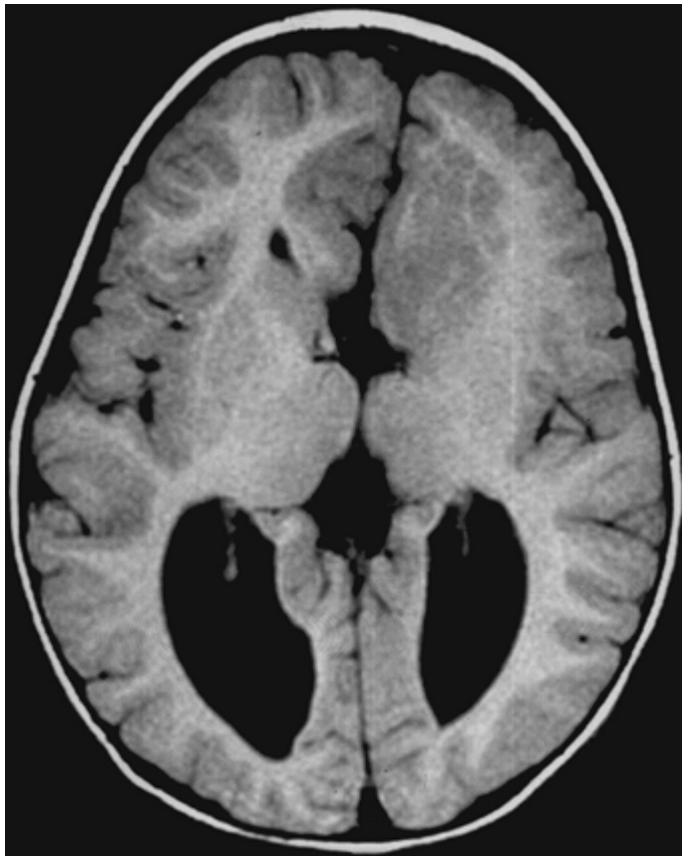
Subcortical nodular heterotopia. Axial T1-weighted magnetic resonance image shows large subcortical mass of gray matter in the mesial frontal lobe associated with partial agenesis of corpus callosum and ventricular changes.
